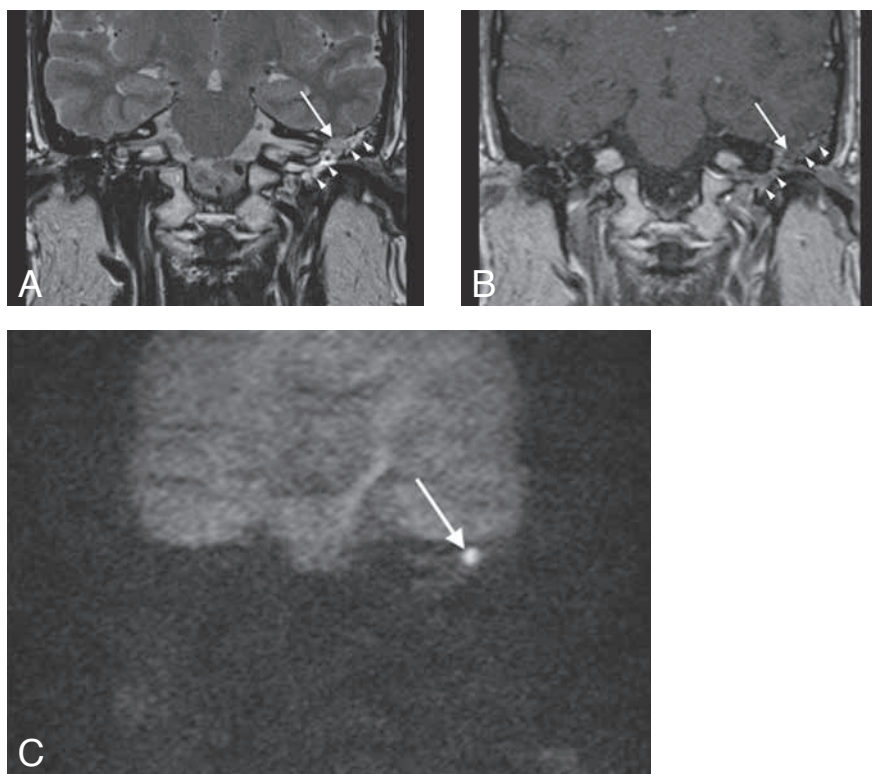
Coronal MR imaging of an attic cholesteatoma in the left middle ear with surrounding inflammation in a 42-year-old man.
